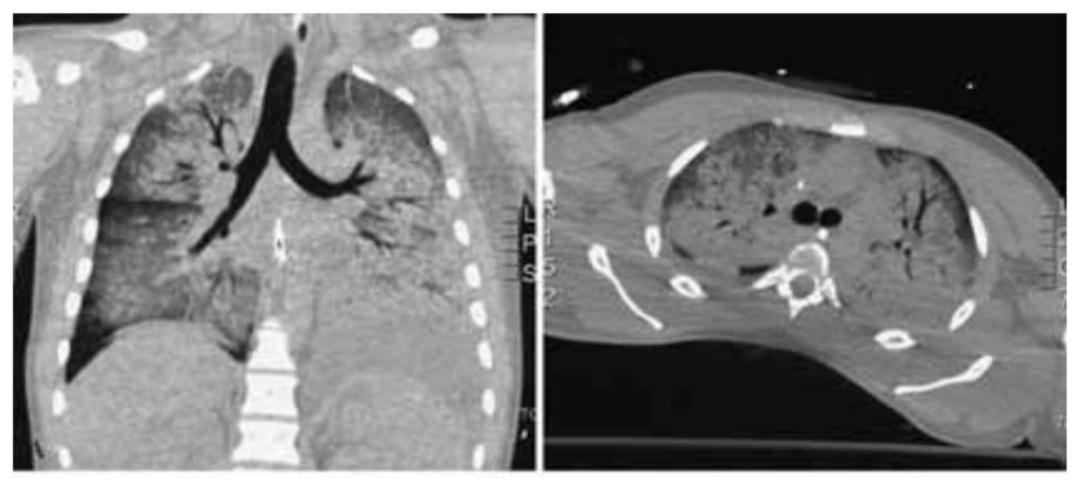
A) Chest CT-scan obtained immediately after admission to our ICU: massive bilateral consolidation with air bronchogram are visible; B) Chest CT-scan obtained before discharge shows a partial resolution with residual areas of ground-glass and fibrotic strias.
